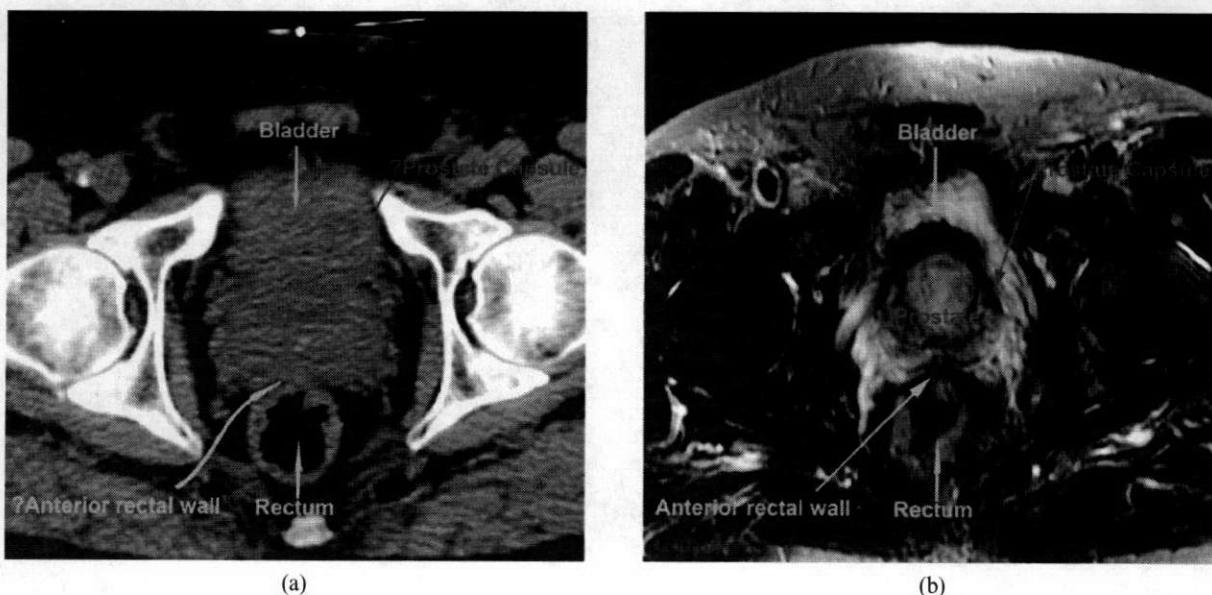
A comparison of transaxial co-registered views of the pelvis for prostate radiotherapy with (a) CT and (b) MR in the same patient. The boundaries of the prostate are better visualized using MR than with CT, notably the anterior rectal wall/recto-vesical fascia and prostate capsule.
